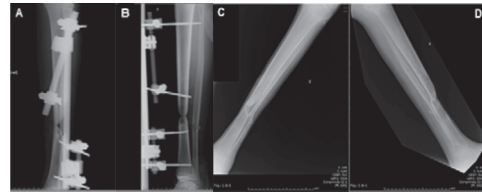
Radiographic images relating to patient number 16, who received satisfactory definitive surgical treatment with an external fixator. A and B - Radiographic images from the immediate postoperative period, in AP and lateral views, respectively, of a fracture of the tibial diaphysis treated with an external fixator. C and D - Radiographic images produced 28 weeks after the operation in AP and lateral views, respectively, of a consolidated fracture of the tibial diaphysis treated with an external fixator.
